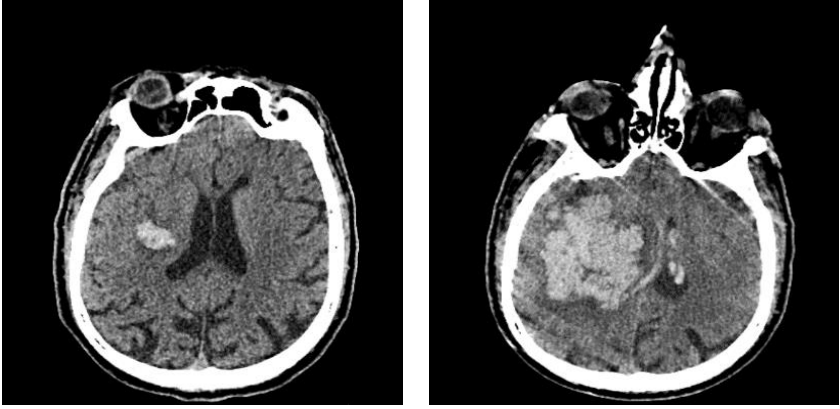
Two cerebral CT-scans showing a small intraparenchymal hematoma (left) and after 7 hours a gigantic hematoma at the same patient (right). (Personal collection of dr. Vicențiu Săceleanu).
